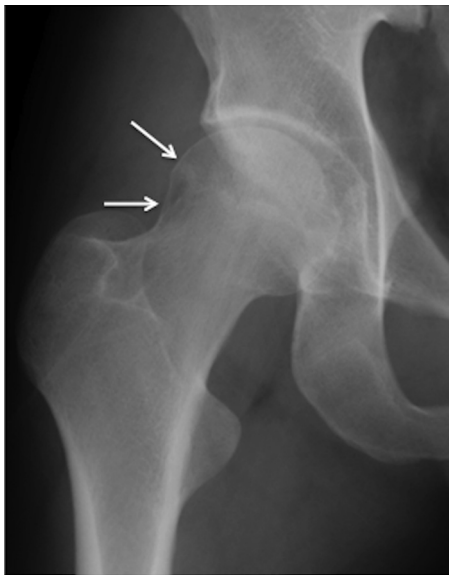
Anteroposterior radiograph after the onset of right hip pain. An anteroposterior radiograph obtained after the onset of right hip pain shows an irregular contour at the outside of the femoral head, around which focal bone loss is observed (white arrows).
